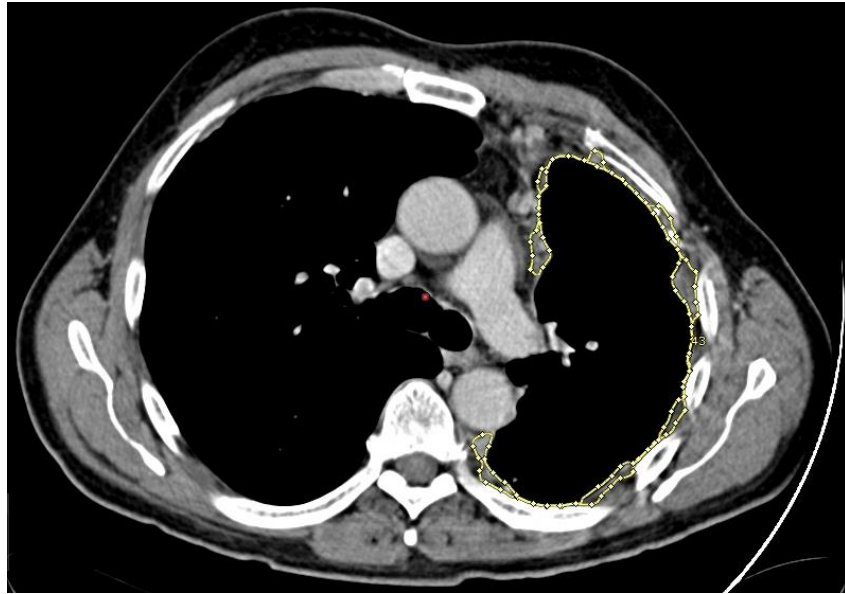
Example of contouring of pleural tumour in the axial slice of a contrast-enhanced CT scan. The yellow area contains what was interpreted as pleural tumour
